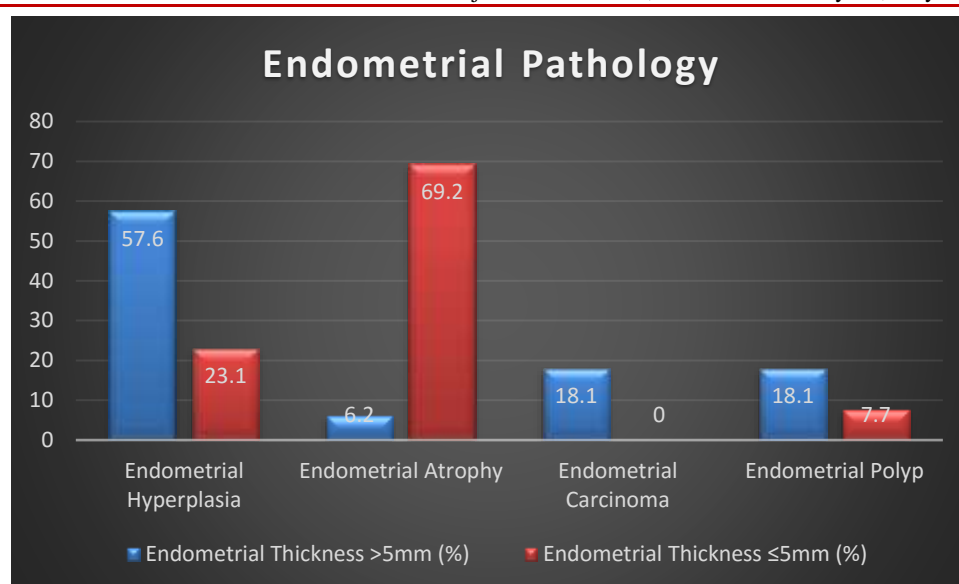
Distribution of Different Types of Endometrial Pathology According to Endometrial Thickness on Transvaginal Ultrasonography (n=46)
